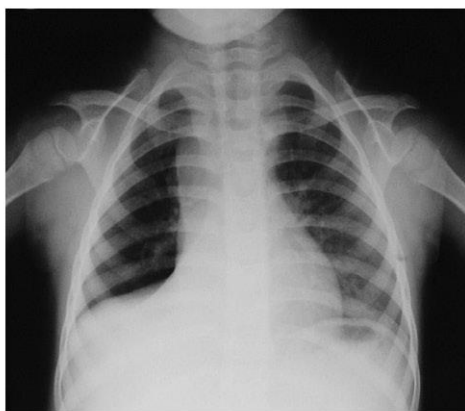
Chest radiograph showing collapse of the right middle and lower lobe. The right hilar nodes are enlarged.
